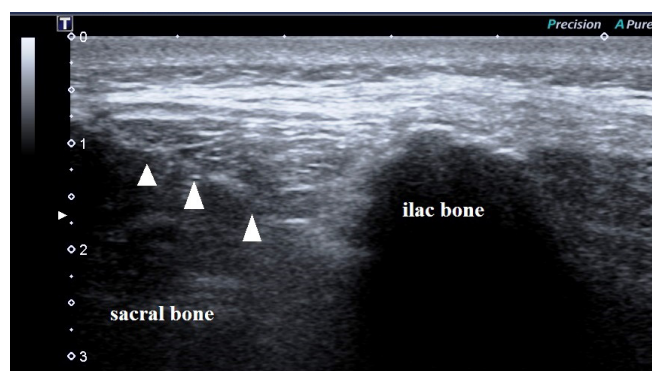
Ultrasonographic guided local injection into the sacroiliac joint in a male patient with inflammatory sacroiliitis on top of radiographic axial spondyloarthritis.
